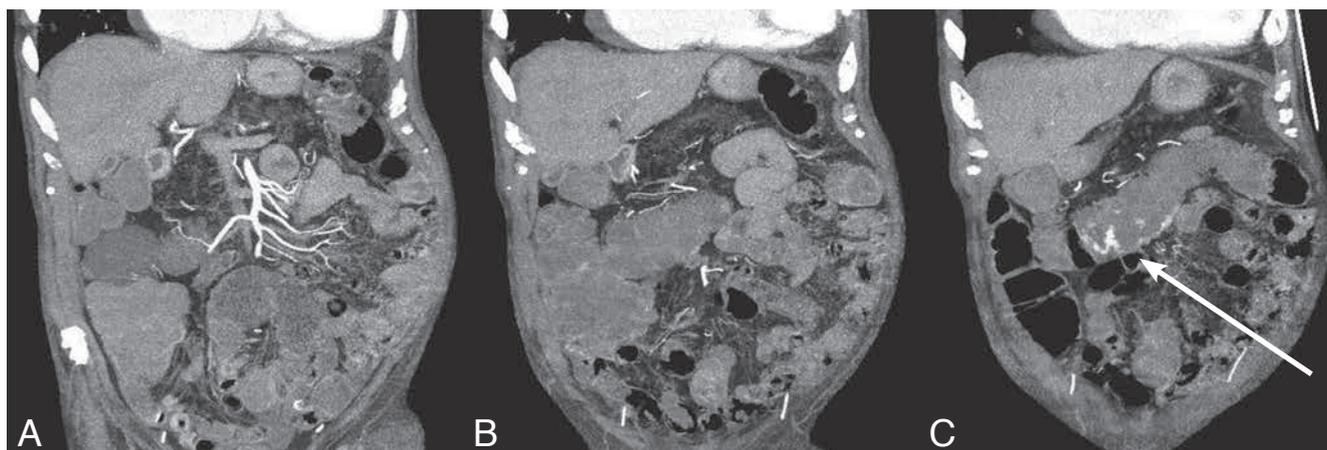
Coronal reconstructed maximum intensity projections of CTA images in arterial phase demonstrate the intraluminal contrast agent (arrow) due to bleeding from the medial colic artery, originating from the superior mesenteric artery.
